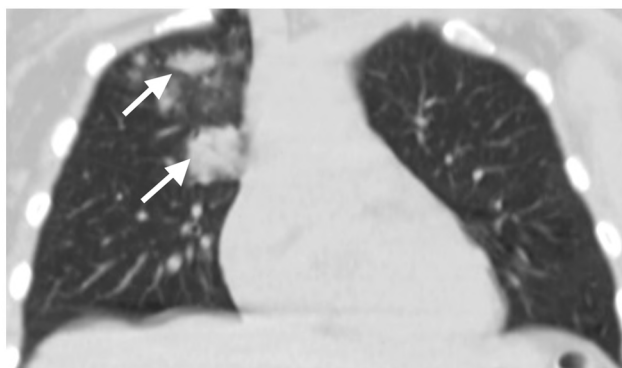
Non contrast coronal CT images in 43 year sold woman imaged 8 days from symptoms onset (late phase), shows multi-focal, unilateral consolidations seen in the RT upper lung lobe, COR-ADS 4.
